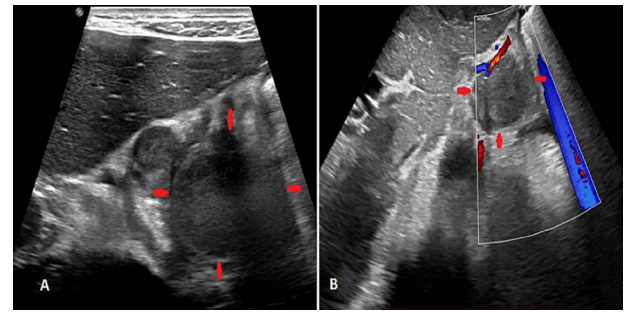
Abdominal ultrasound (A and B) showing a round, heterogeneous, echogenic, well-limited pancreatic mass with discrete peripheral vascularity on color Doppler.
